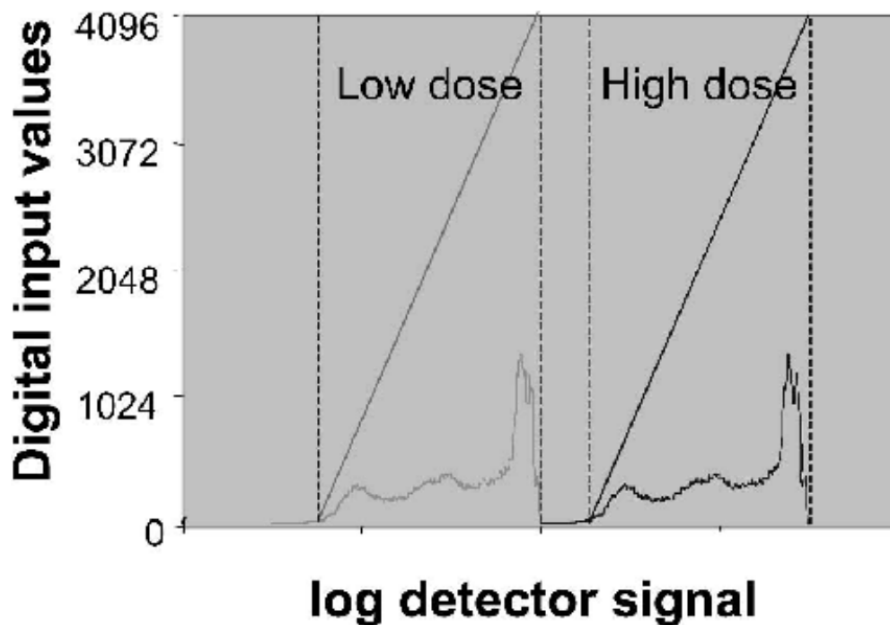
Gradational curves applied to normalize signal over different x-ray doses.[[4](#), Figure 3]
